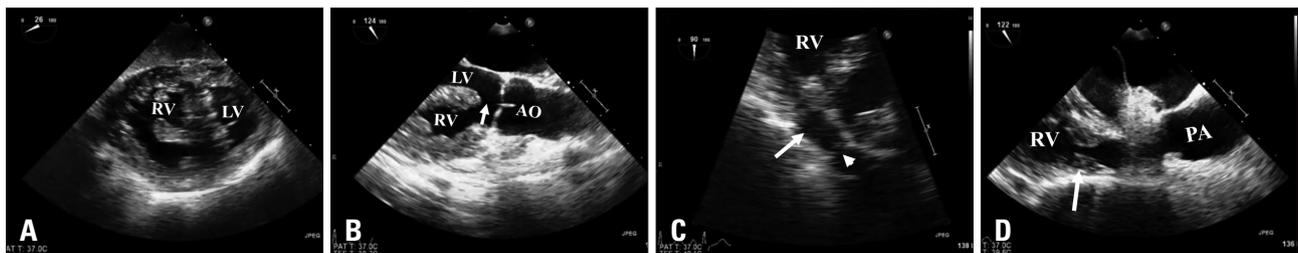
A: Transesophageal echocardiogram (TEE) transgastric view showing dilated right ventricle with significant hypertrophy. B: TEE apical long axis view showing overriding of the ascending aorta with malalignment ventricular septal defect (arrow). C: TEE transgastric view showing hypoplastic right ventricular outflow tract (arrow) with infundibular stenosis. Pulmonic valve is shown (arrowhead). D: TEE modified mid esophageal view showing significant infundibular stenosis (arrow). AO: ascending aorta, LV: left ventricle, PA: pulmonary artery, RV: right ventricle.
